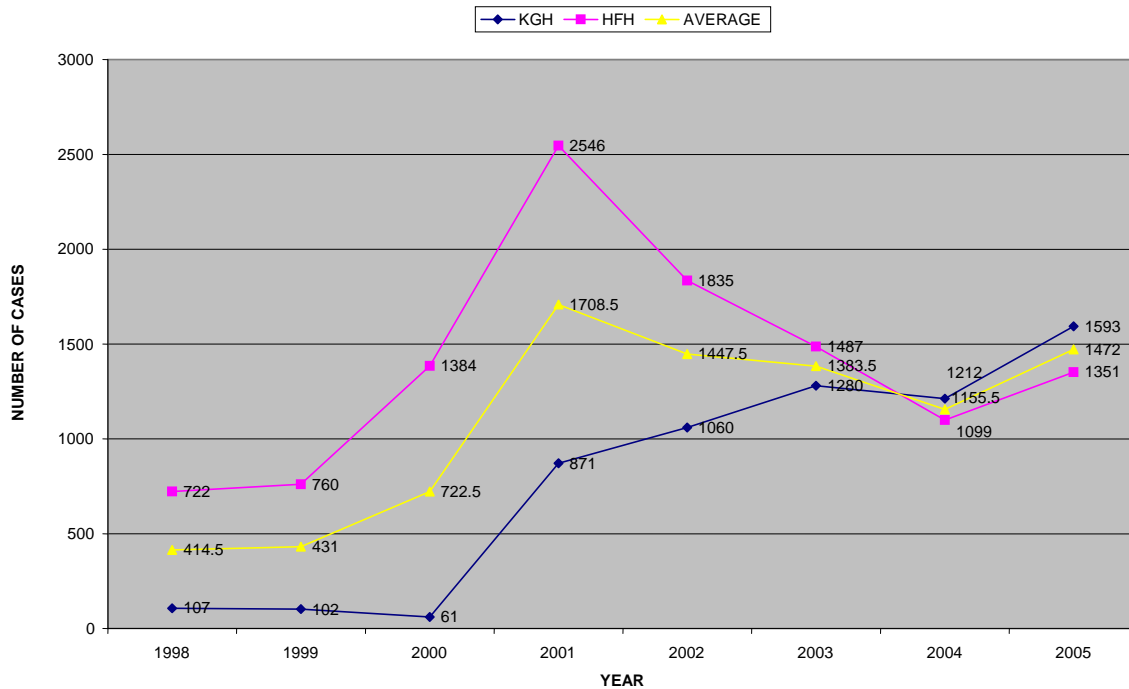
TREND OF UTILISATION OF ULTRASOUND (KGH AND HFH)
